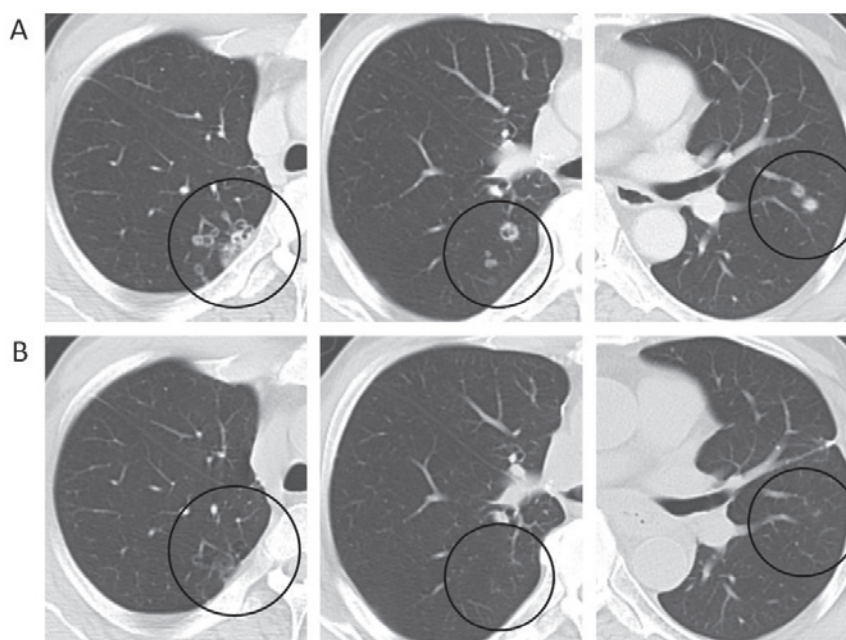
Radiologic appearance before and after the crizotinib treatment. (A) Computed tomography image revealed multiple small nodules in bilateral lung. (B) All small nodules disappeared following treatment with crizotinib.
